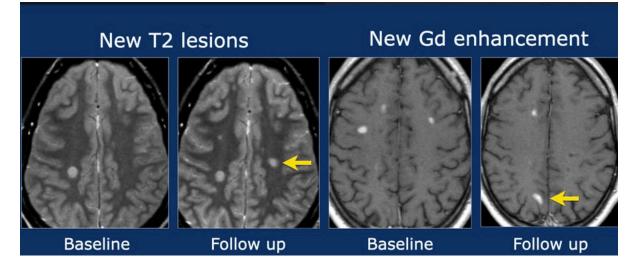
Baseline and interval MRI images in MS. The images demonstrate new WMLs using T2 sequences (left) and T1 with enhancement (right). Lesions appear bright in both protocols (Barkhof and Smithuis, 2021).
